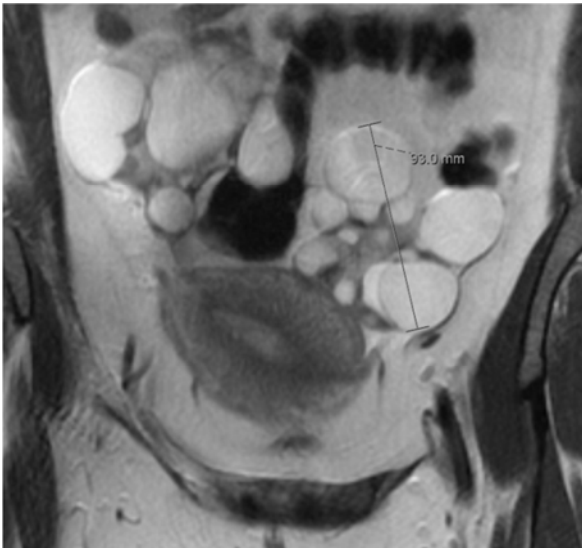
MRI abdomen revealing bilateral large multilocular pelvic cystic masses measuring 13.8x9.2cm on the right and 12.4x6.8cm on the left.
